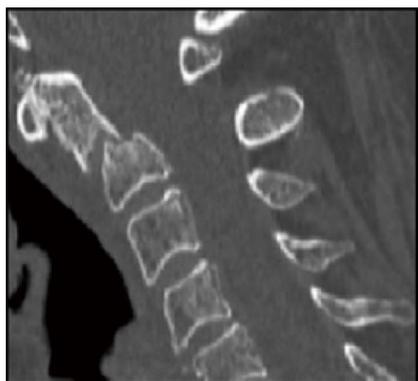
Computed tomography-scan at admission to the hospital showing a transverse fracture line above C2 vertebral body and below transverse ligament of the odontoid process (type II fracture).
